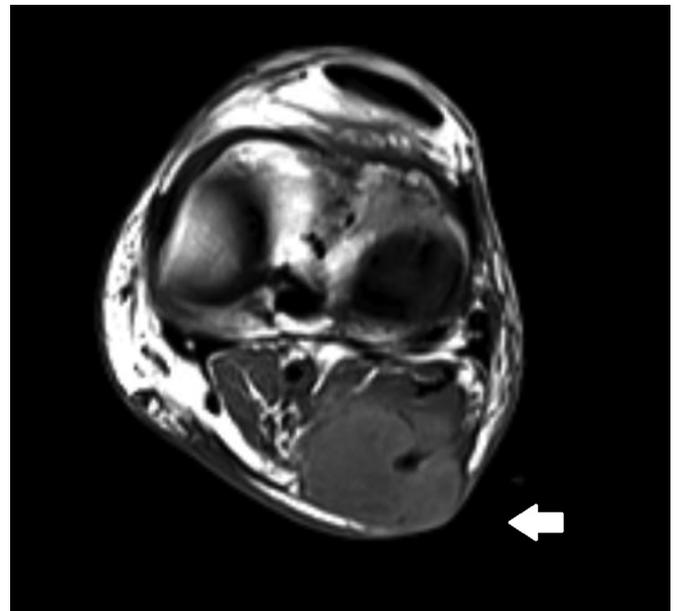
Left Lower extremity, MRI without contrast, T1 Axial view: Fluid collection in the popliteal fossa extending to the skin surface.
